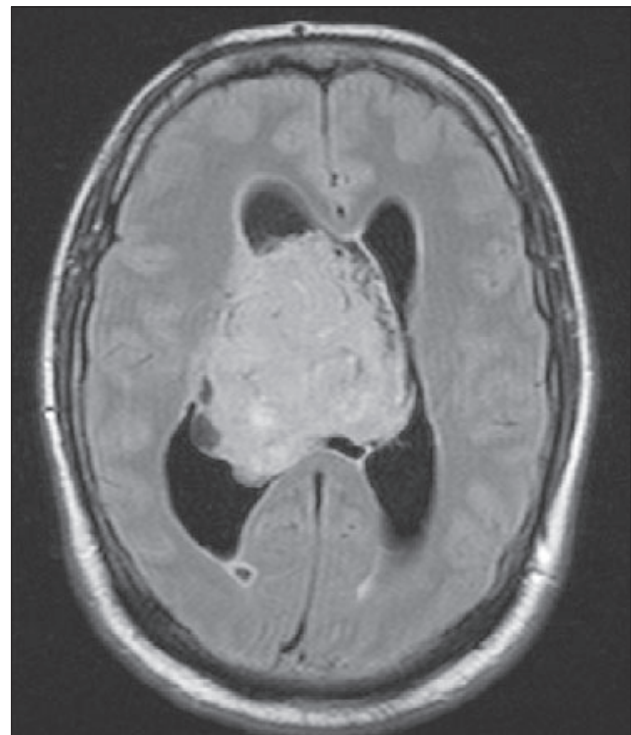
MRI, FLAIR transversal section shows a spacious tumour in both lateral ventricles.
